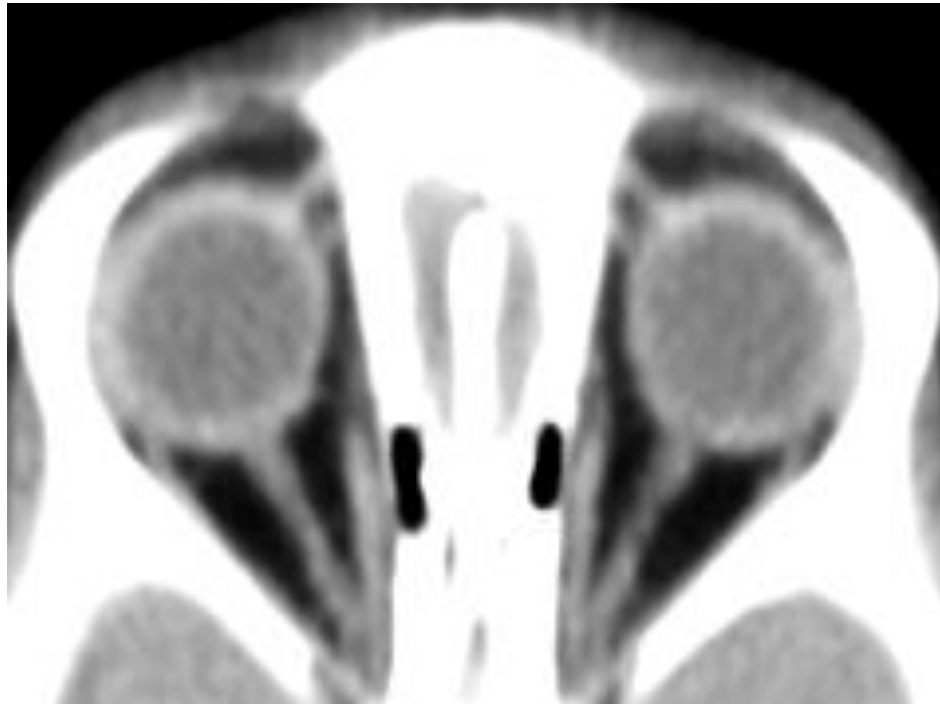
Axial CT scan demonstrating the ONS
